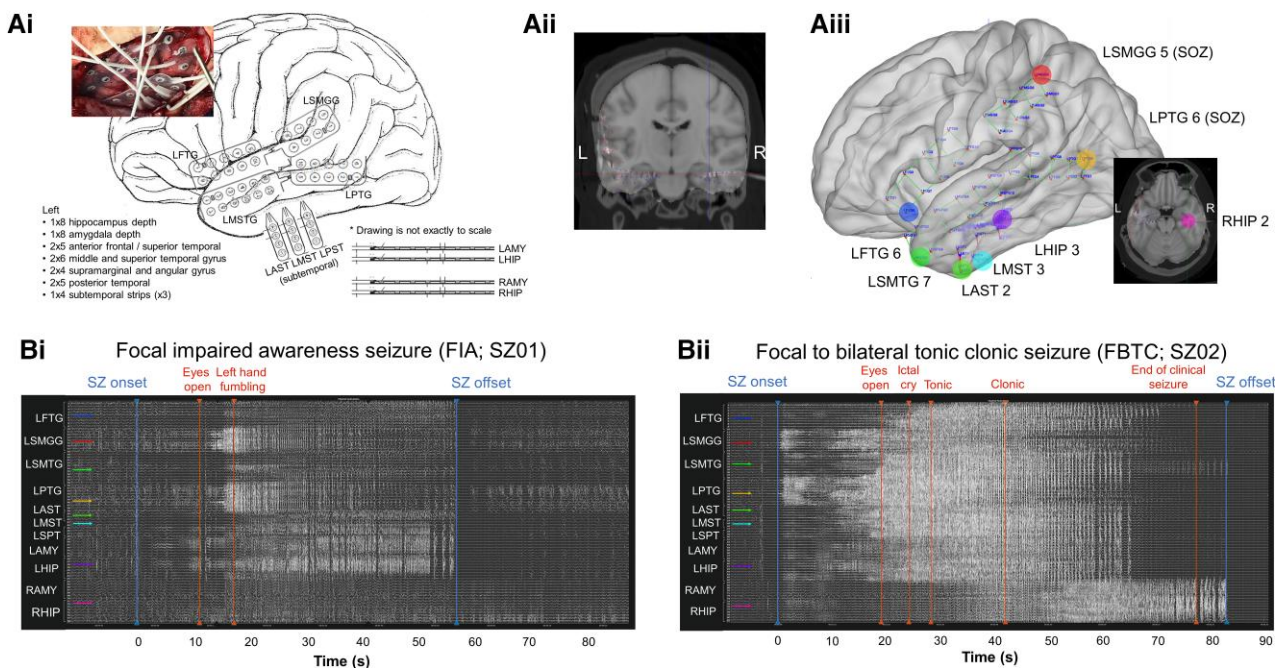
Exemplar 3D localization of intracranial electrodes and iEEG signal for one FIA and one FBTC seizure originating from a representative patient. (A) The surgical implantation and clinical electrode map (i) are used to locate electrodes positions in the post-implantation CT and pre-implantation MRI images, aligned in MNI standard space using the iElectrodes software (ii); eventually, final electrodes localizations are displayed on a standard MRI template (iii). (B) Time courses of raw iEEG signals for (i) one FIA and (ii) one FBTC seizure, along with marked behavioural events. Arrows indicate electrodes, with the locations specified with filled circles in [A(iii)]. Contacts LSMGG 5 and LPTG 6 were identified as belonging to the SOZ.
